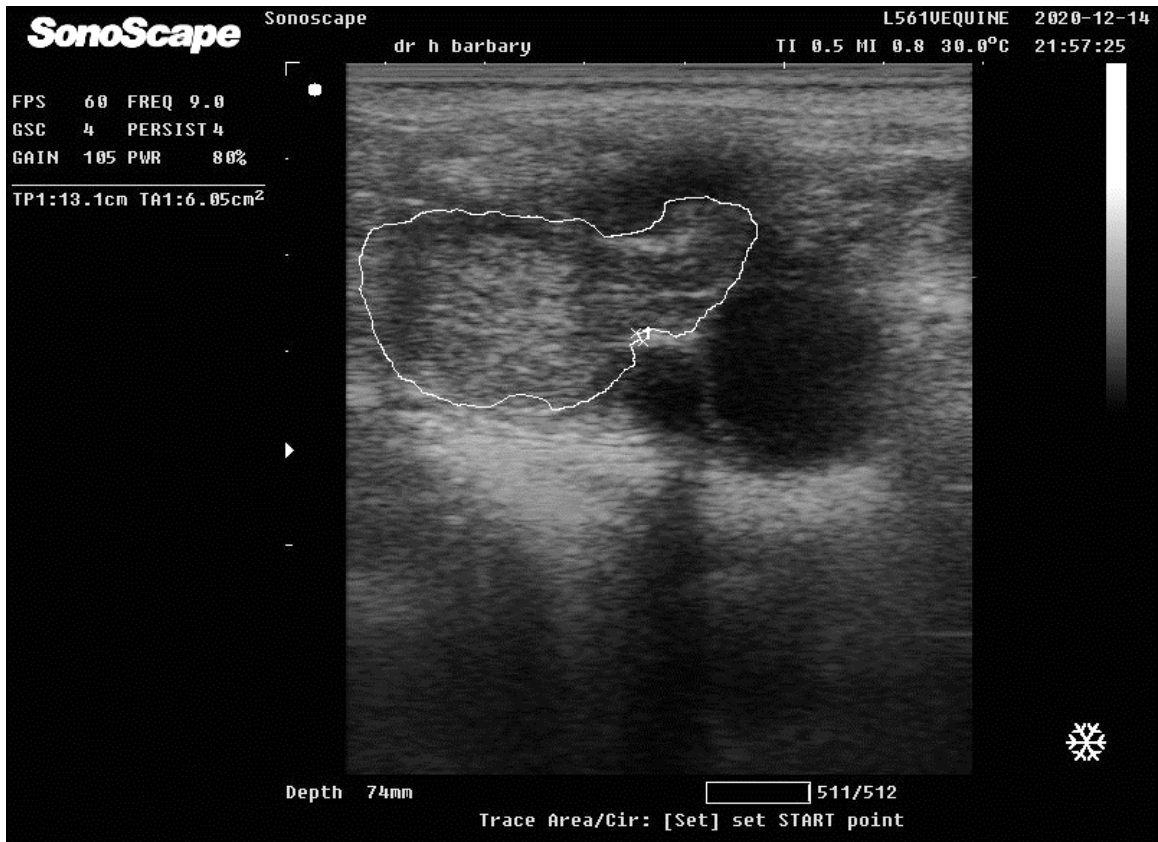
Ultrasonographic image of compact CL
